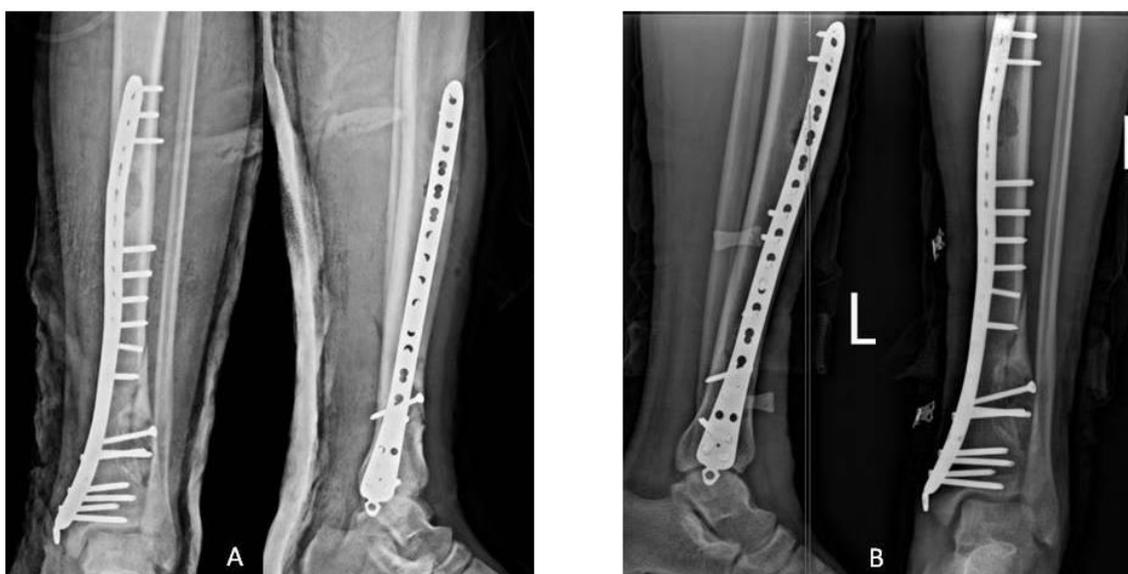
Immediate Postoperative radiography (A), 3-month postoperative follow-up X-ray (B)
